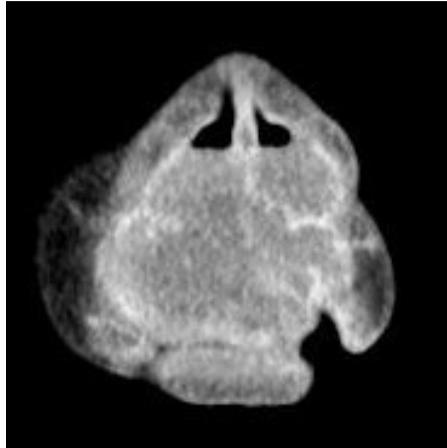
The CT scan performed at the first visit.
